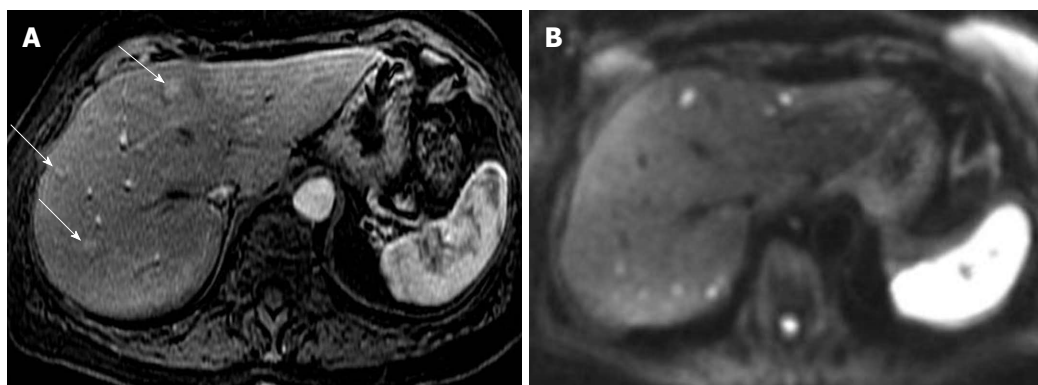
Neuroendocrine metastases to liver. A: Axial arterial phase post contrast T1-weighted (T1W) gradient recalled-echo; B: Diffusion-weighted image (DWI). Only 3 enhancing metastatic lesions are seen on the post contrast T1W image. DWI increases conspicuity of these lesions and also shows many more bilobar high signal metastatic lesions with impeded diffusion.
